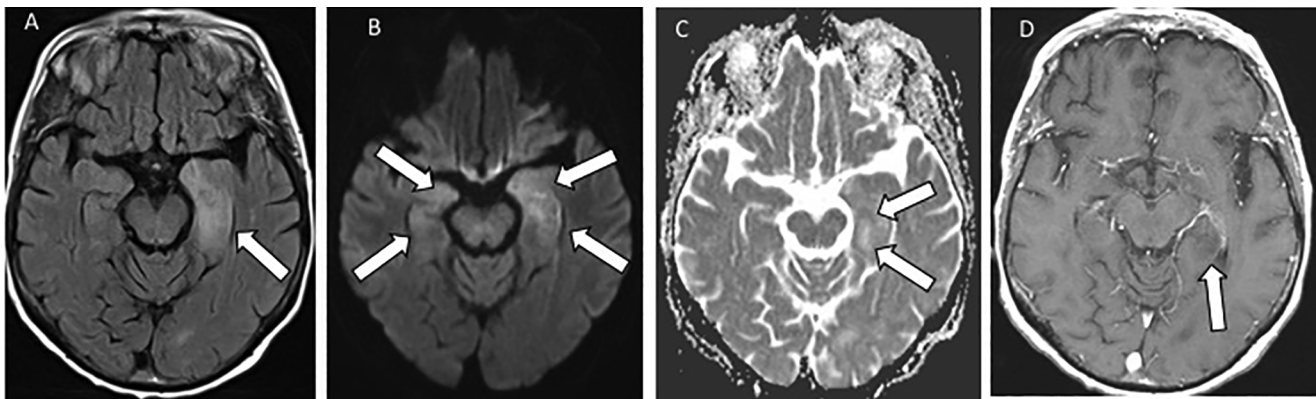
Case 2, MRI head 12 days after the onset of altered mental state: white arrows show the signal hyperintensity changes in the limbic system, predominantly in the left amygdala and hippocampus on FLAIR (A), partial restricted diffusion (B, C) and T1 hypointensity on post-Gadolinium-enhanced T1-weighted image (D).
